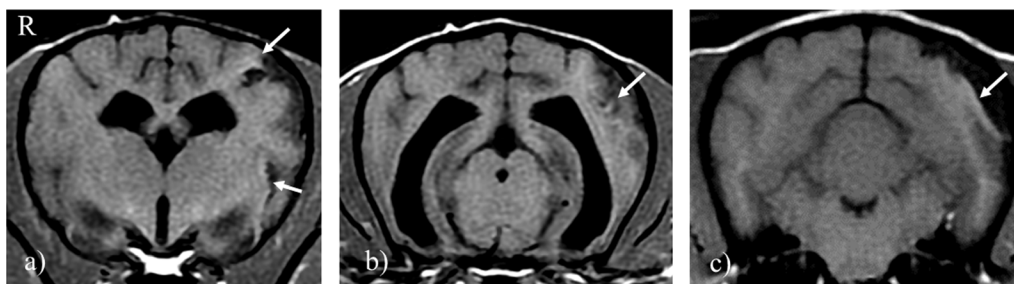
The periphery of the cortical lesion on T1-weighted imaging (WI). These images showed a), b) Transverse images acquired on T1WI at the temporal lobe level on day 39 after epilepsy onset and c) Transverse image on T1WI at the occipital lobe level on day 133 after epilepsy onset. The center of lesion was hypointensity, but the periphery of the cortical lesion was hyperintense on T1WI slightly (arrow). R, right; T1WI, T1-weighted imaging.
